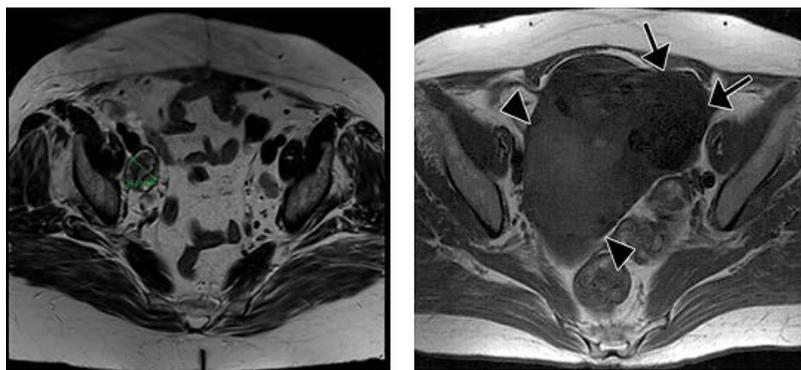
Pelvis MRI scans (26/09/2011): left ovarian mass with the uterine body extension and right external iliac lymph nodes.
